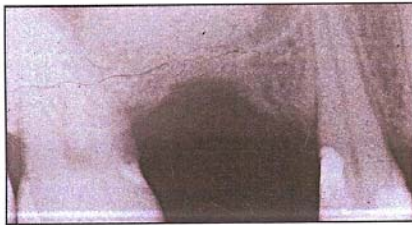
Radiograph at completion of CCE procedure demonstrating 8 to 10 mm of localized sinus floor elevation.
